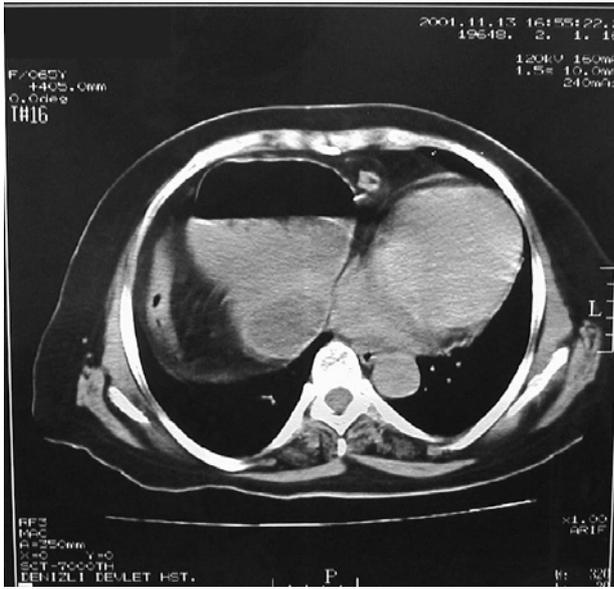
CT of the thorax showed a paracardiac hernia containing stomach.
